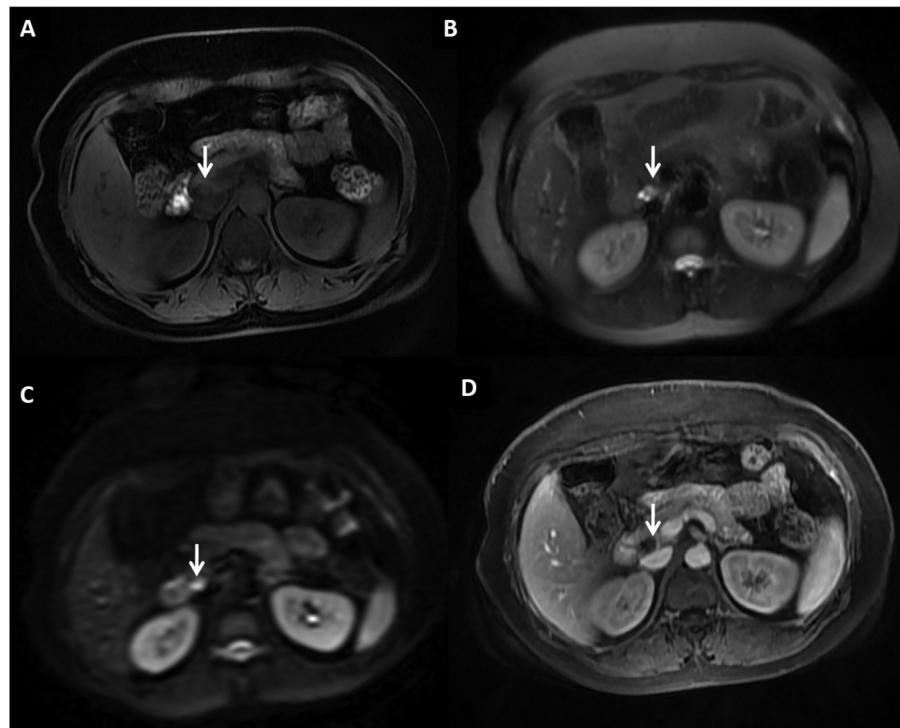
A 43-year-old-female with incidentally detected lymphoepithelial cyst postcholecystectomy in the pancreas. (A) Axial T1-weighted magnetic resonance imaging showing unilocular cystic lesion, which is mildly hyperintense in the head of the pancreas (B) and hyperintense on T2-weighted images (C), showing bright signal on diffusion-weighted imaging (D) with no enhancement on T1-weighted postcontrast gradient echo images.
